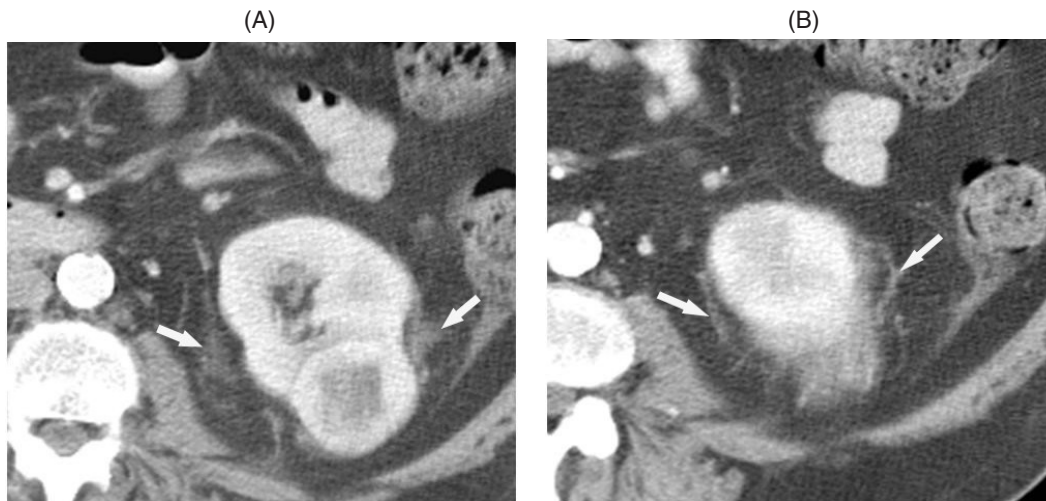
Perinephric stranding (arrows) seen extending from this solid left lower pole renal cell carcinoma, leading to a false positive CT staging of a T3 tumor: at pathology there was no perinephric extension, thereby downstaging this to a T1.
